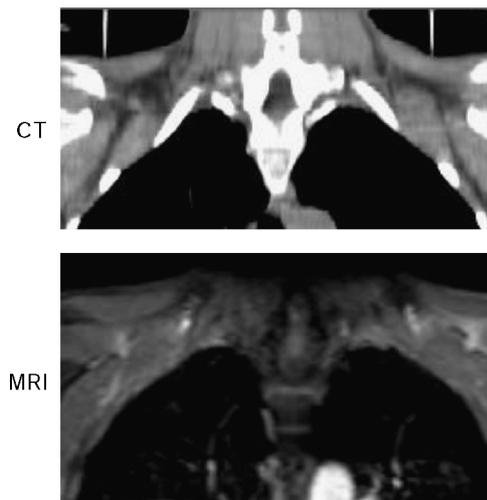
Example images (coronal slices) from computed tomography (CT) (upper image) and magnetic resonance imaging (MRI) (lower image). Adipose tissue stands out as dark gray both in CT and in MRI images. On the basis of CT and MRI findings, white and brown adipose tissues cannot be distinguished from each other.
